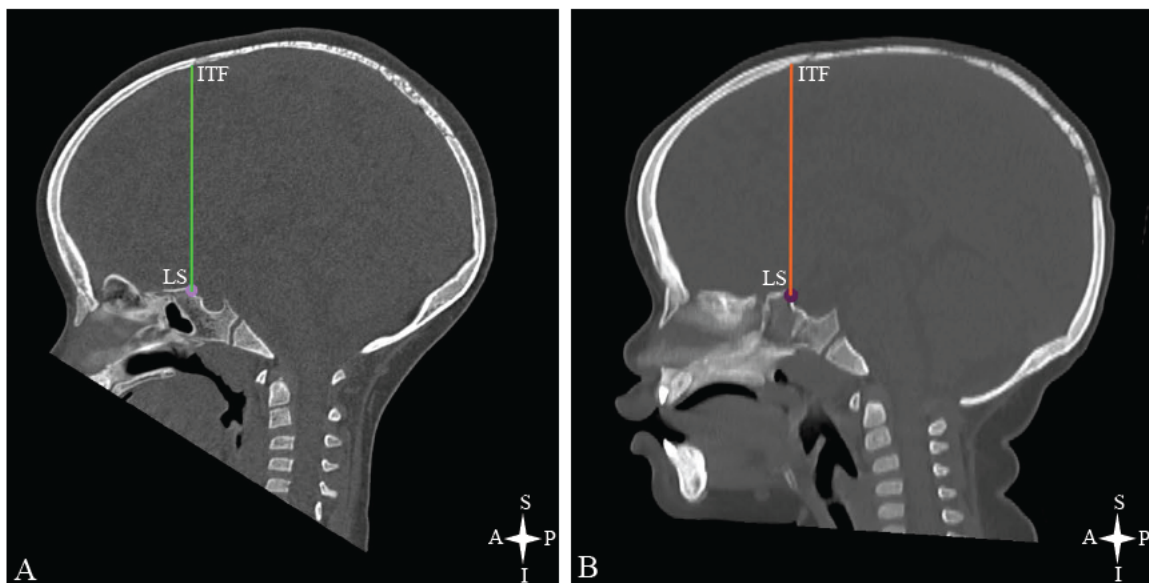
ACF height on a sagittal CT scan of a normal patient (A) and trigonocephaly patient (B) (height: LS to ITF). Key: LS – midpoint of limbus sphenoidale; ITF – inner table of frontal bone
